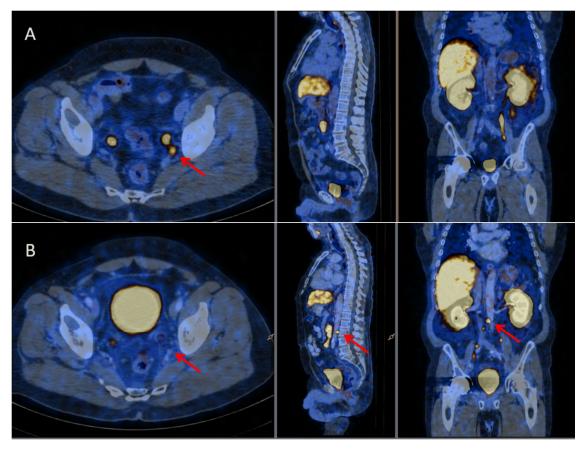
A PSMA PET (A) in this man with Gleason score 9 PC, PSA 0.23ng/mL, treated with initial RP 12 months prior demonstrates a PSMA positive left obturator node (red arrow). The patient subsequently underwent sRT to the prostate fossa and pelvic nodes. However, the PSA did not respond and repeat PSMA PET 10 months later (B) demonstrates treatment response in the left obturator lymph node, but multiple new PSMA avid lymph nodes (red arrow) immediately above the sRT treatment field, extending superiorly to the para-aortic region.
